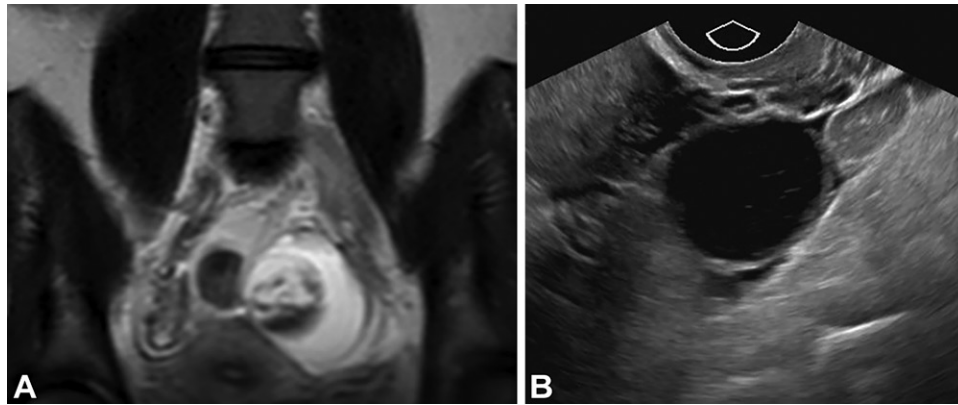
Cyst larger than 3 cm in a premenopausal woman at MRI that requires additional characterization. (A) Coronal T2-weighted abdominal MR image in a woman with polycystic kidney and liver disease shows a 5.2-cm left ovarian cyst containing hypointense components. The cyst was only visualized on the large field-of-view sequence from abdominal MRI (abdominal structures cropped from image). From this single image, it could not be determined if the T2-hypointense signal in the cyst was artifactual or represented other noncystic internal components. Therefore, US was recommended for further characterization. (B) US image obtained 1 month later shows a smaller 2-cm cyst containing fine reticular echoes consistent with a resolving hemorrhagic cyst.
